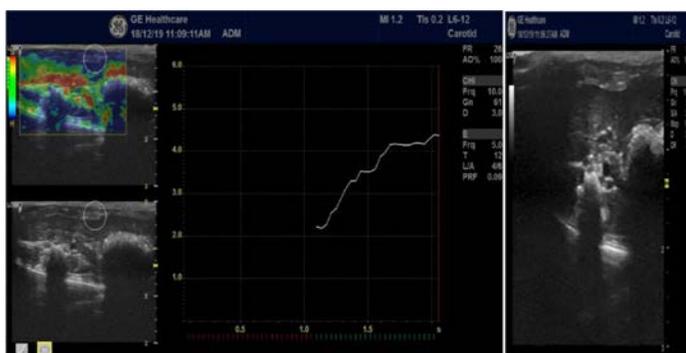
Elastography and Ultra sonography of C100. Liver size: 2.0 cm. Elastographic score (pKa-4.2)
